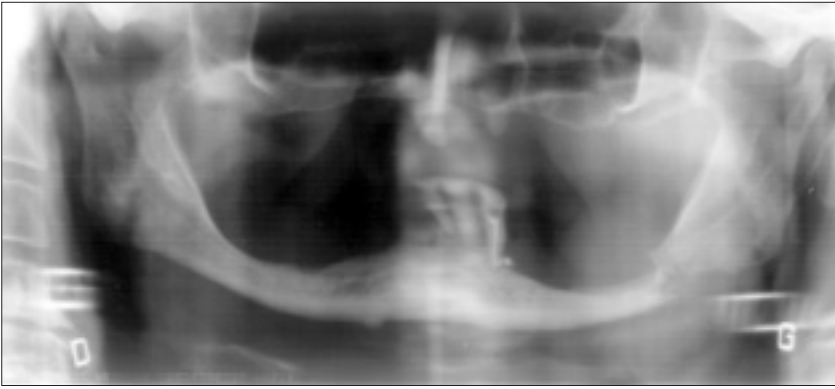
Panoramic radiograph demonstrates displacement of the fragments of mandibular bone.
